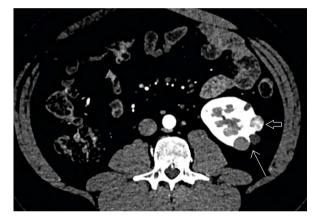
Axial contrast-enhanced computed tomography (CT) image shows complex cystic left renal mass (large arrow) and multiple simple renal cysts (small arrow)
